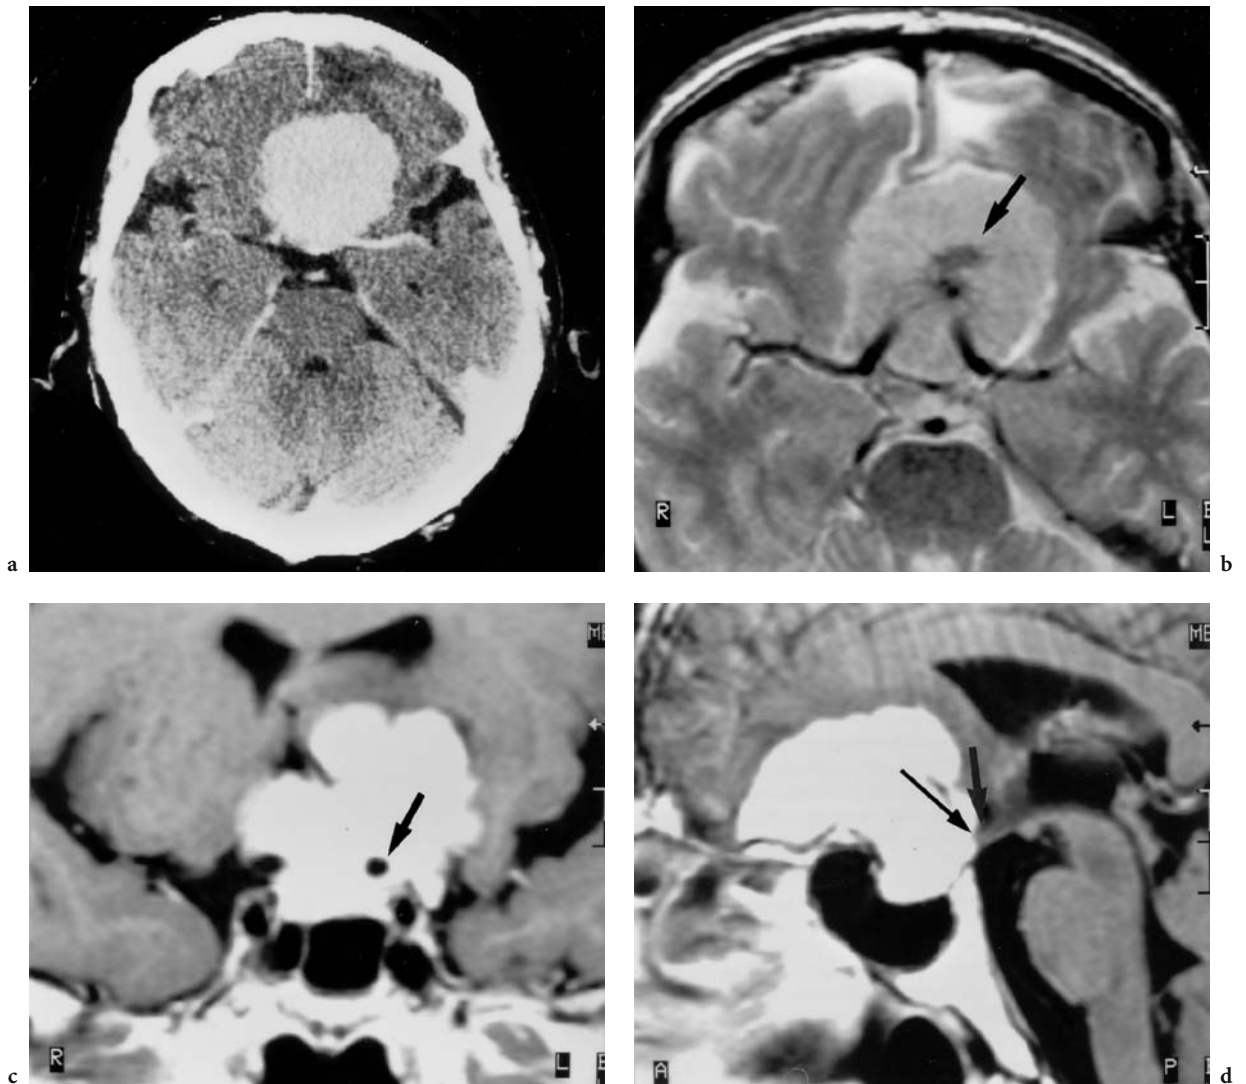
A 69-year-old man with slowly progressing bilateral visual deficit with emphasis to the left. Diagnosis: meningioma of the sphenoid plane. Axial, contrast-enhanced CT: a Homogeneous enhancement of a spherical tumor with emphasis to the left is seen at the posterior part of the frontal base. Note a slight perifocal edema in the left frontal white matter. MRI: b Corresponding T2-weighted view with displacing growth of the extraparenchymal tumor, indicative of the so-called tumor “belly” (arrow). Note hyperintensity of the left frontal white matter, due to perifocal edema (compare with a) c Coronal T1-weighted, contrast-enhanced view with clearly visible homogeneous tumor enhancement and a knotty tumor surface. Only slight narrowing of the left ICA (arrow), located in the medial region of the meningioma. d Midsagittal, T1-weighted, contrast-enhanced image where the origin of the meningioma is distinguished by thickening of the secondary curved sphenoid plane. Note intrasellar tumor expansion with compression of the pituitary stalk at the dorsum sellae (arrows). (From MÜLLER-FORELL and LIEB 1995)
